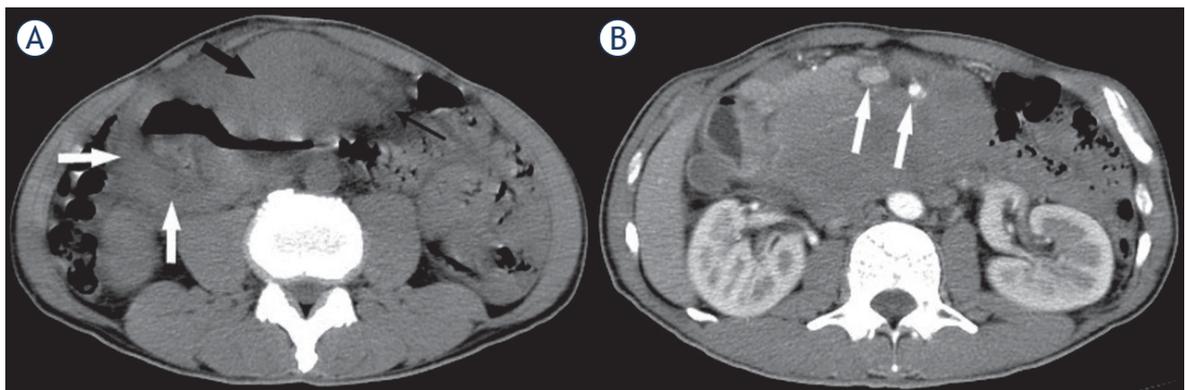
A 61-year-old man with PTCL in the duodenum. (A) Axial non-contrast CT image shows the thickening of the duodenal wall (white arrows). The lesion grows in an expansive centripetal fashion (black arrow) with an ill-defined margin and invasion of adjacent fatty tissue (thin black arrow). (B) Contrast-enhanced CT image shows the tumor with heterogeneously mild enhancement. Superior mesenteric artery and vein are encased by the tumor (white arrows). Tumor progression was found during therapy. This patient deceased at 5 months after therapy.
